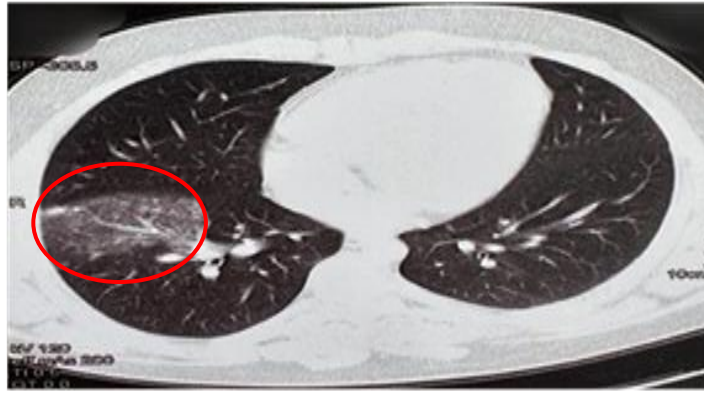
Thoracic CT Scan showing right basal pneumonia
